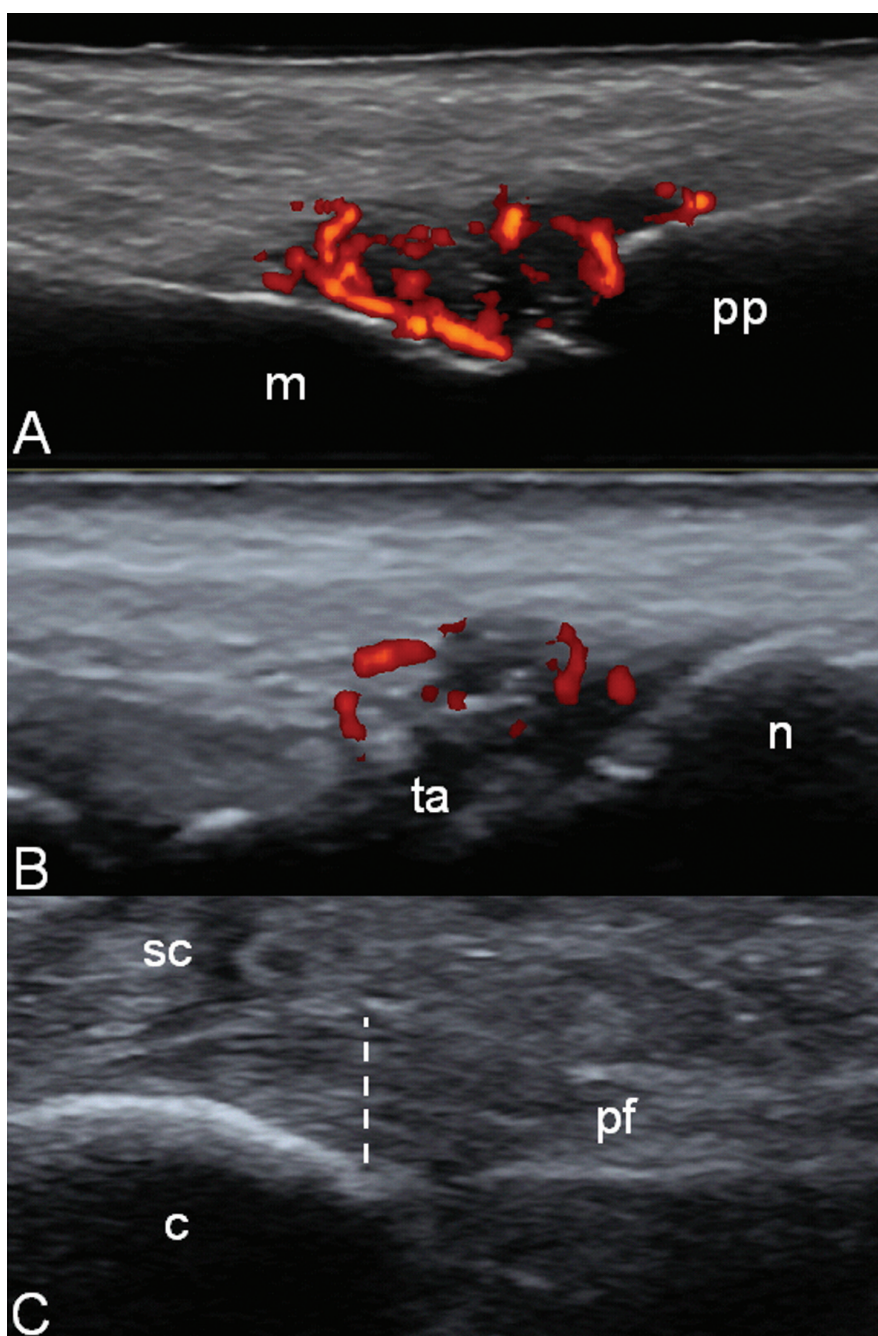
Psoriatic arthritis. Foot. A. Synovitis of the second metatarsophalangeal joint in longitudinal dorsal scan. Evident joint cavity widening due to synovial hypertrophy showing intense power Doppler signal. B. Synovitis of the talo-navicular joint in longitudinal dorsal scan showing mild joint cavity widening with mild intra-articular power Doppler signal. C. Plantar fasciitis in longitudinal plantar scan. The image shows the fusiform swelling of the plantar fascia. The vertical white line indicates where thickness measurement (6 mm) was taken. m: metatarsal bone; pp: proximal phalanx; ta: talar bone; n: navicular bone; c: calcaneal bone; pf: plantar fascia; sc: subcutaneous tissue.
